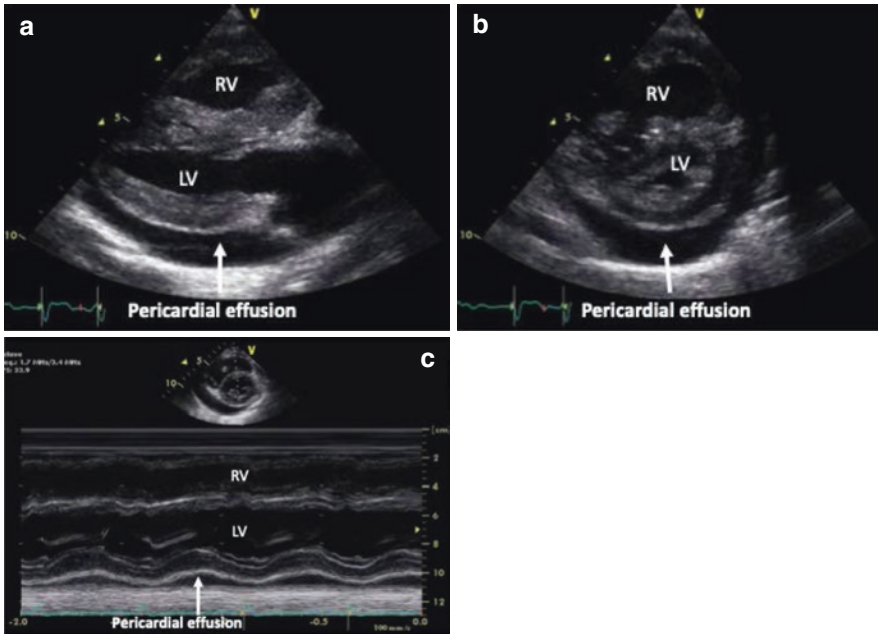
Pericardial effusion on 2D parasternal long axis (PLAX) view (a), parasternal short axis (PSAX) view (b), and in M-mode in PSAX view (c). *LV* left ventricle, *RV* right ventricle, *LA* left atrium
